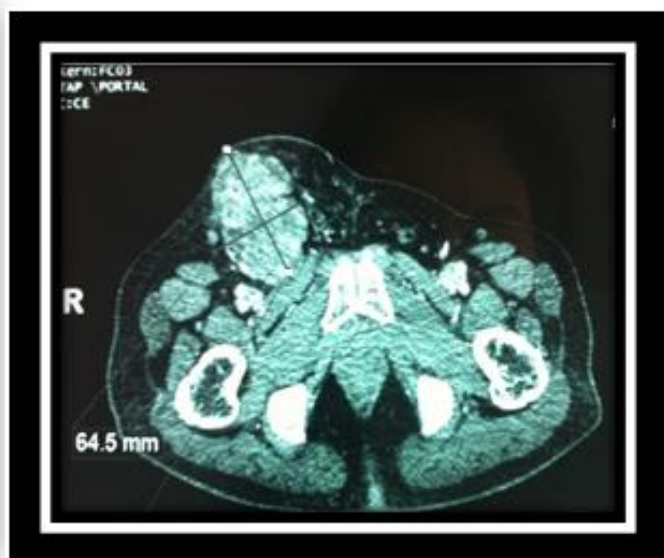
Initial computed tomography scan showing the right inguinal and iliac pathologic lymphadenopathy
